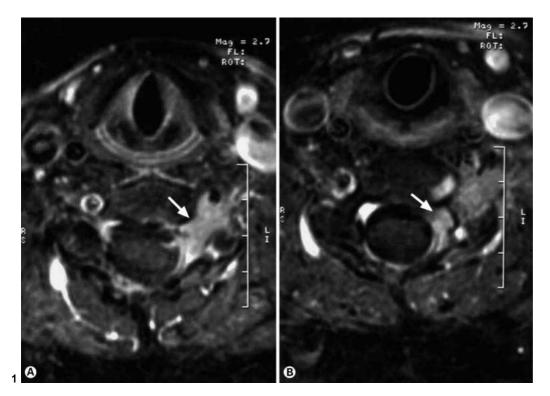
A 71-year-old female presented with neck pain and numbness in her left arm. One year after resection of a C6 spinal meningioma, a T1 contrast-enhanced sagittal MRI showed tumor recurrence (arrow) extending out the neural foramen (A). The patient was treated with Cyberknife radiosurgery using 20 Gy delivered in one fraction. At 6 months, the tumor (arrow) was smaller on MRI (B) and the patient remained clinically unchanged.
